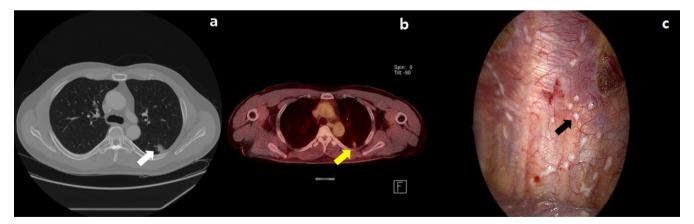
Chest CT showing a 1.9cm part-solid, pleural-based mass in LLL superior segment (white arrow) (a). PET CT showing a subsolid lesion with mild hypermetabolism in LLL (yellow arrow) (b). A few white flat nodules on parietal pleura (black arrow) (c).
